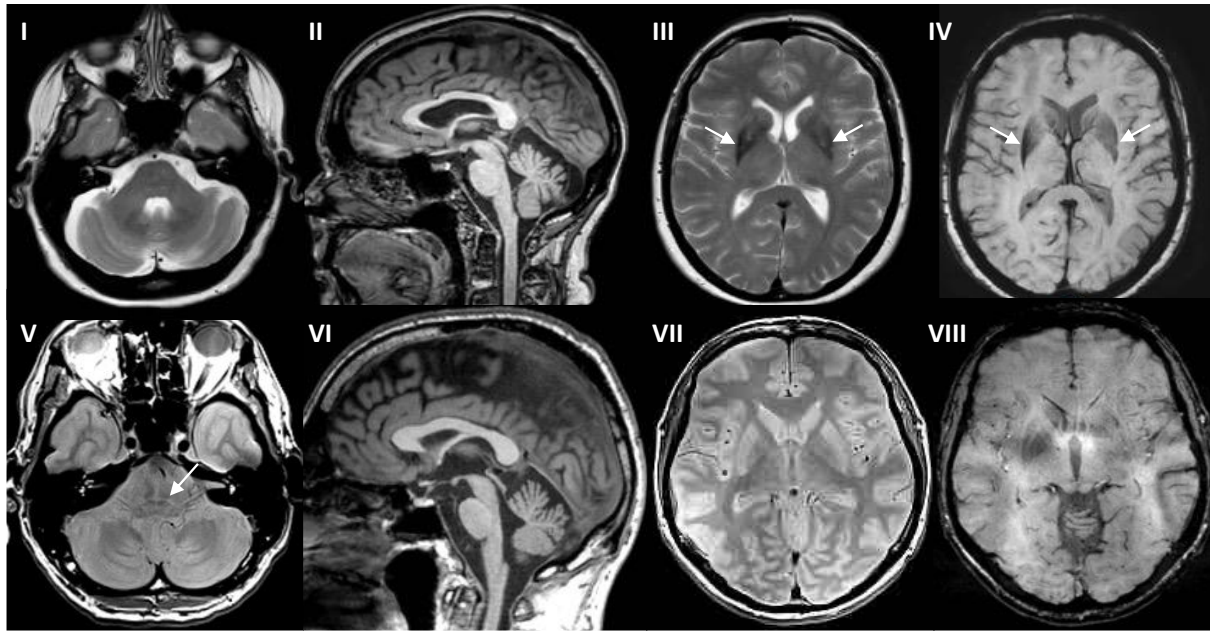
MRI features in *FGF14* (*GAA*)_{≥300} patients with MSA. The top panels show MRI features in case of C1 at age 59, one year from symptoms onset, and the bottom panels show MRI features in P3 at age 55, five years from symptoms onset. Panels I and III: axial T2-weighted images, II and VI: sagittal T1-weighted images, V and VII: axial proton-density images, IV and VIII: axial susceptibility-weighted images. Case C1 had a clinically established MSA-P diagnosis and *FGF14* (*GAA*)₃₅₃ repeat expansion. Case P3 had a neuropathologically established MSA-mixed diagnosis and *FGF14* (*GAA*)₃₂₆ repeat expansion. “Hot-cross bun” signs (panels I and V) and cerebellar atrophy (panels II and VI) are present in both cases, more pronounced in case P3. The hypointensity of the putamen in C1 is seen in panels III and IV.
